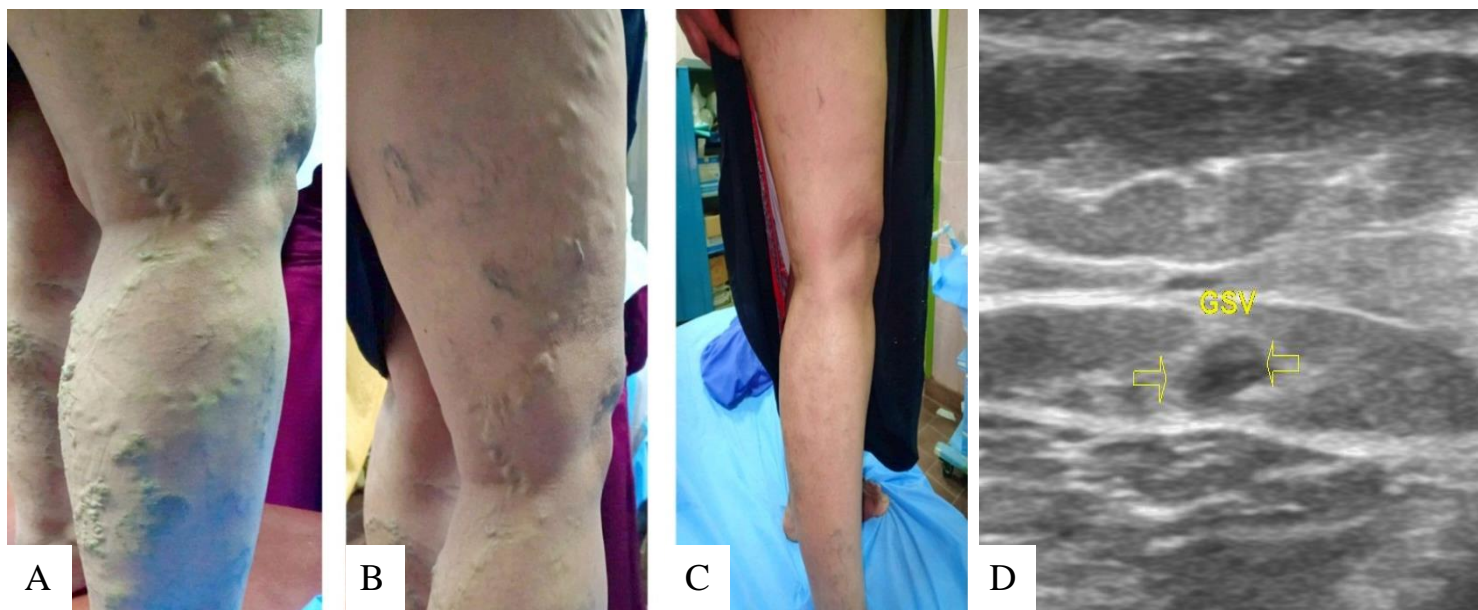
Case no. 2: (A) (B) marked visible varicosities. (C) After three sessions of UGFS, Showing significant improvement. (D) Ultrasound study, the GSV thrombosed and non-compressible with marked reduction in diameter.
